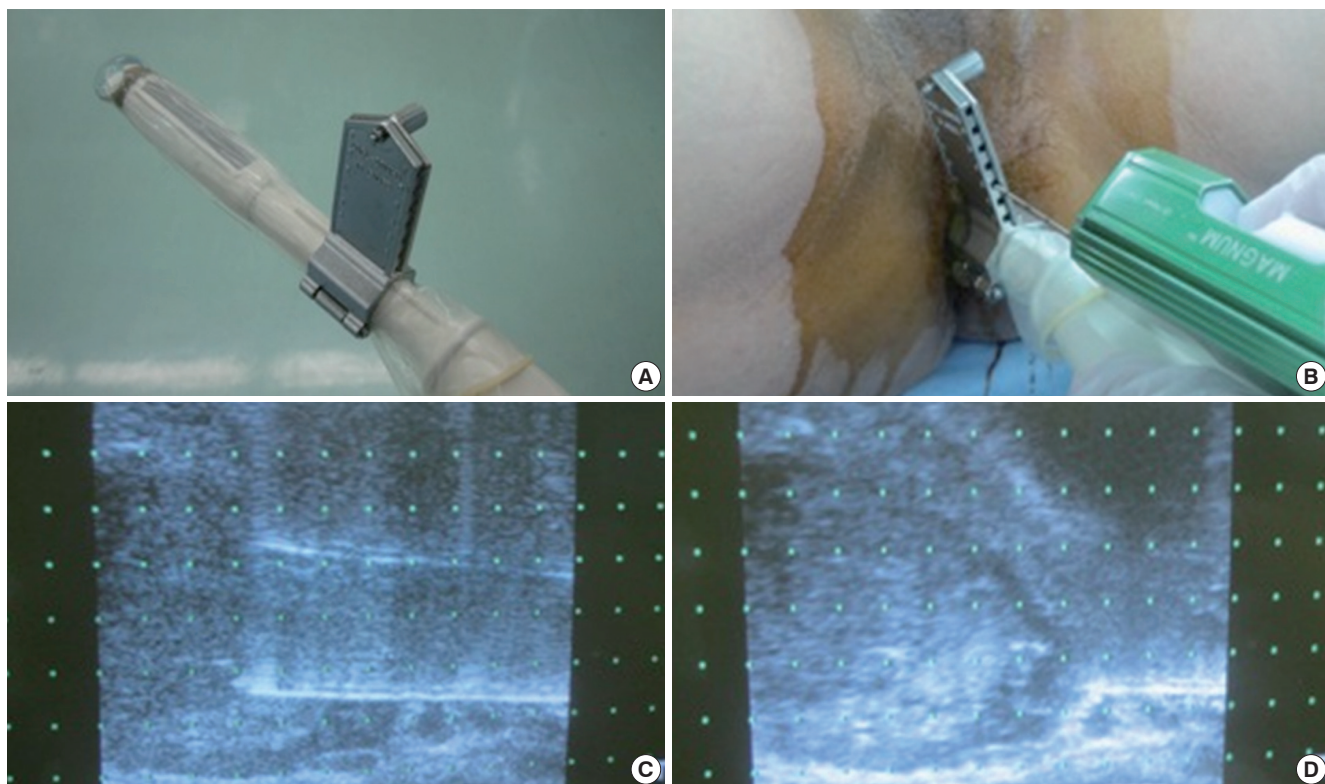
(A) Ultrasound probe and adapter, (B-D) transperineal prostate biopsy.
